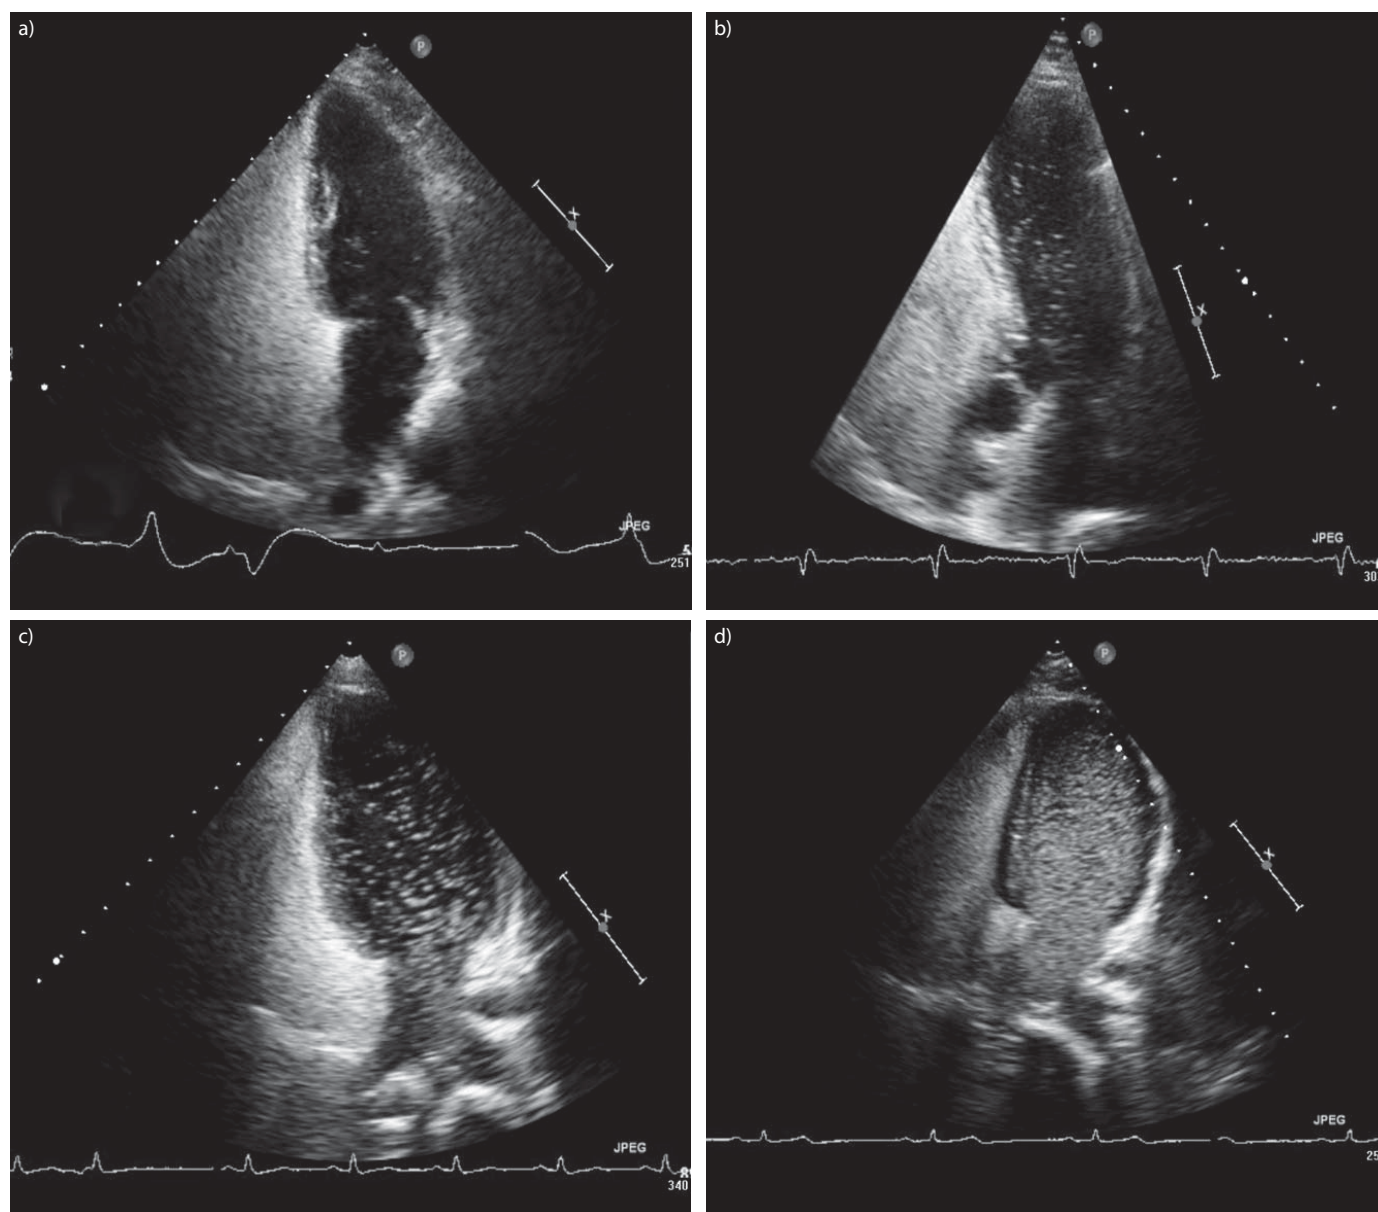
Transthoracic contrast echocardiography grades 1 to 4 with minimal (a), moderate (b), extensive (c) and extensive with endocardial definition (d) amount of contrast in left heart cavities.
